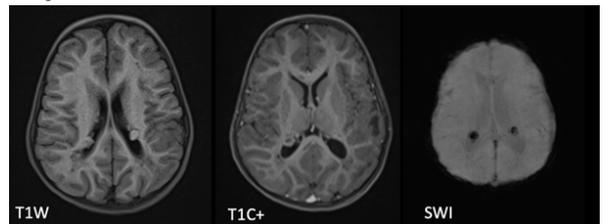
MRI brain showed multiple subependymal nodules along the bilateral lateral ventricles appearing hyperintense on T1W images. Few of these nodules showed enhancement after contrast administration. Some nodules showed blooming on SWI - calcified subependymal hamartomas.
